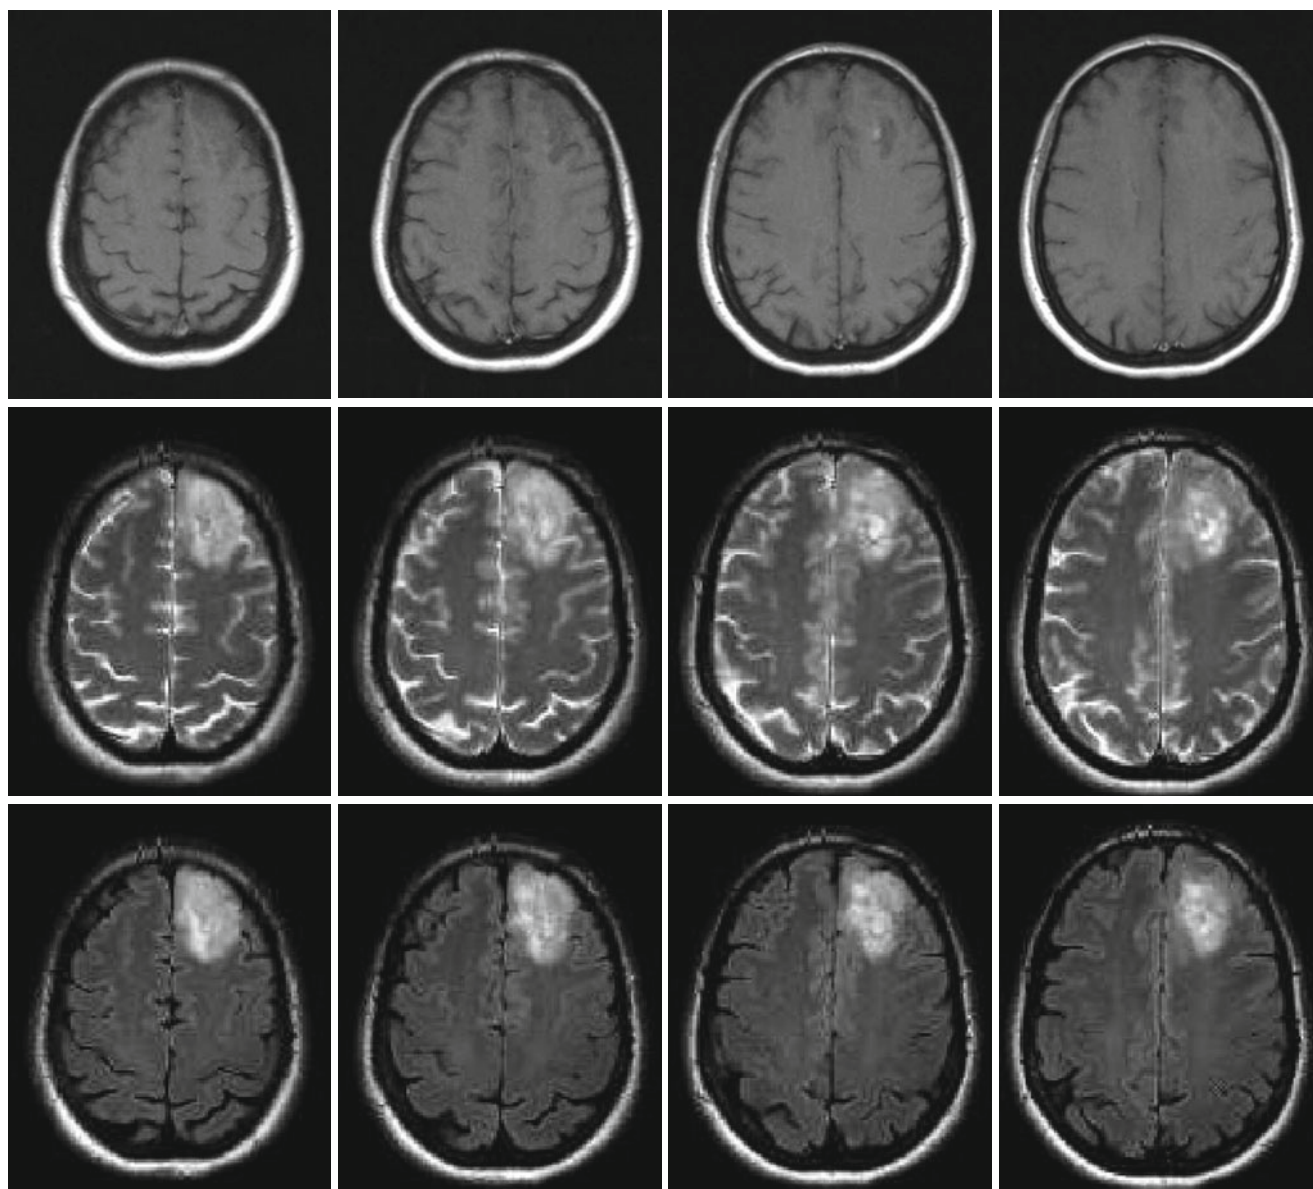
Left frontal low-grade glioma in different MR sequences; female, 51 years. – native T1 (*top*), T2 (*middle*), and FLAIR (*bottom*) sequences (Courtesy of the Institute of Clinical Radiology, Münster)
